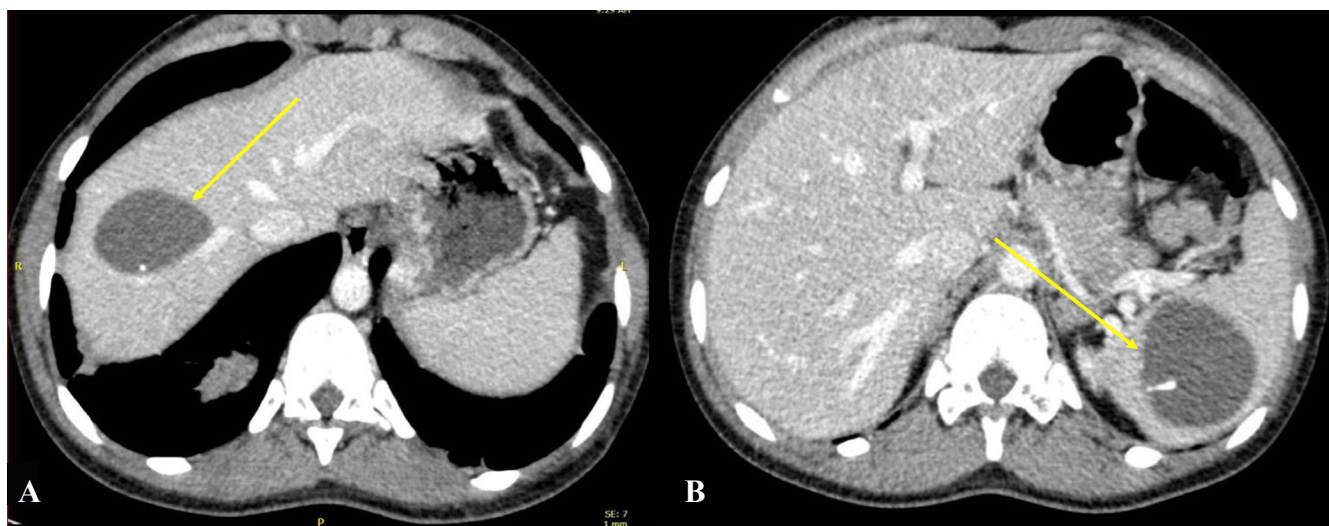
A CT scan from 2023 showing hydatid cysts in the liver (picture A) and spleen (picture B)
